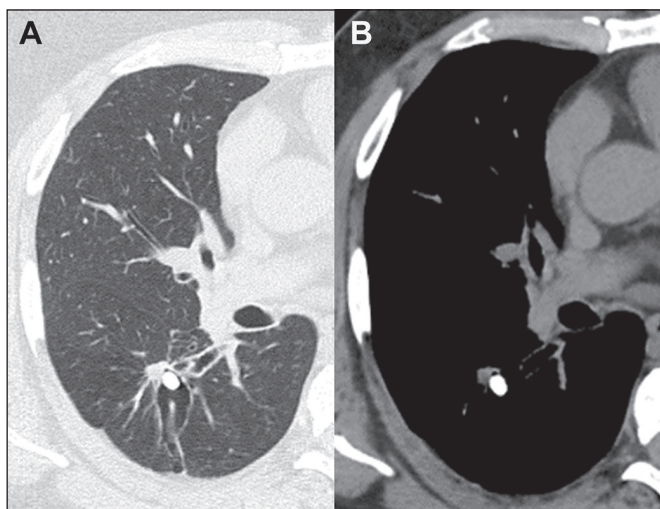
CT of a 51-year-old man with cough and dyspnea, diagnosed with bronchiectasis. Note the bronchiectasis, encompassing a small calcified nodule, in the right lower lobe.
